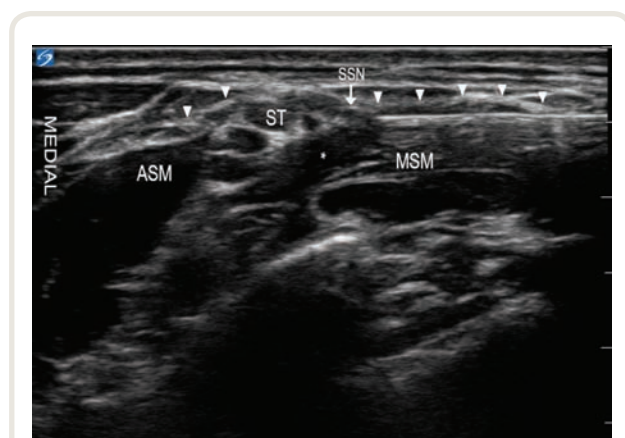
Ultrasongraphic image of the superior trunk block. At the level of the superior trunk, the suprascapular nerve (SSN, arrow) is visible in this individual on the lateral side of the superior trunk. The block needle was advanced in-plane in the lateral-to-medial direction until the needle tip was just adjacent to the lateral boarder of the superior trunk. Local anesthetic (*) was injected around the superior trunk. ASM, anterior scalene muscle; MSM, middle scalene muscle; ST, superior trunk. White down-pointing triangles indicate the deep cervical fascia.
